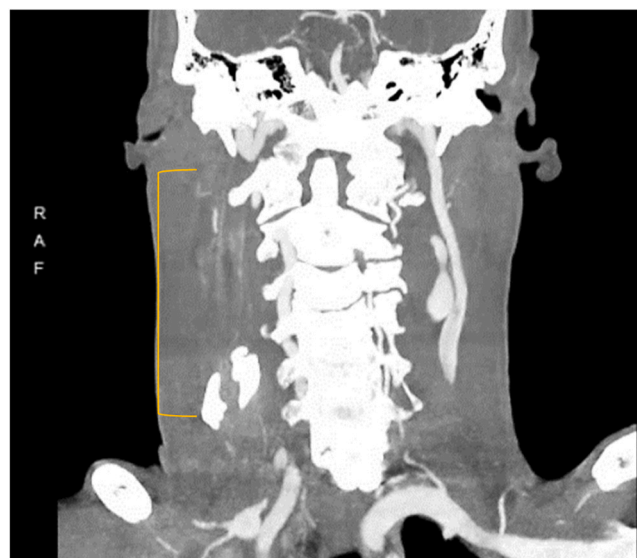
POD-2 CTA Neck Coronal view: Occlusive thrombus in Right Internal Jugular vein from level C1 to C5 base; no abscess reaccumulation or thrombus extension.
